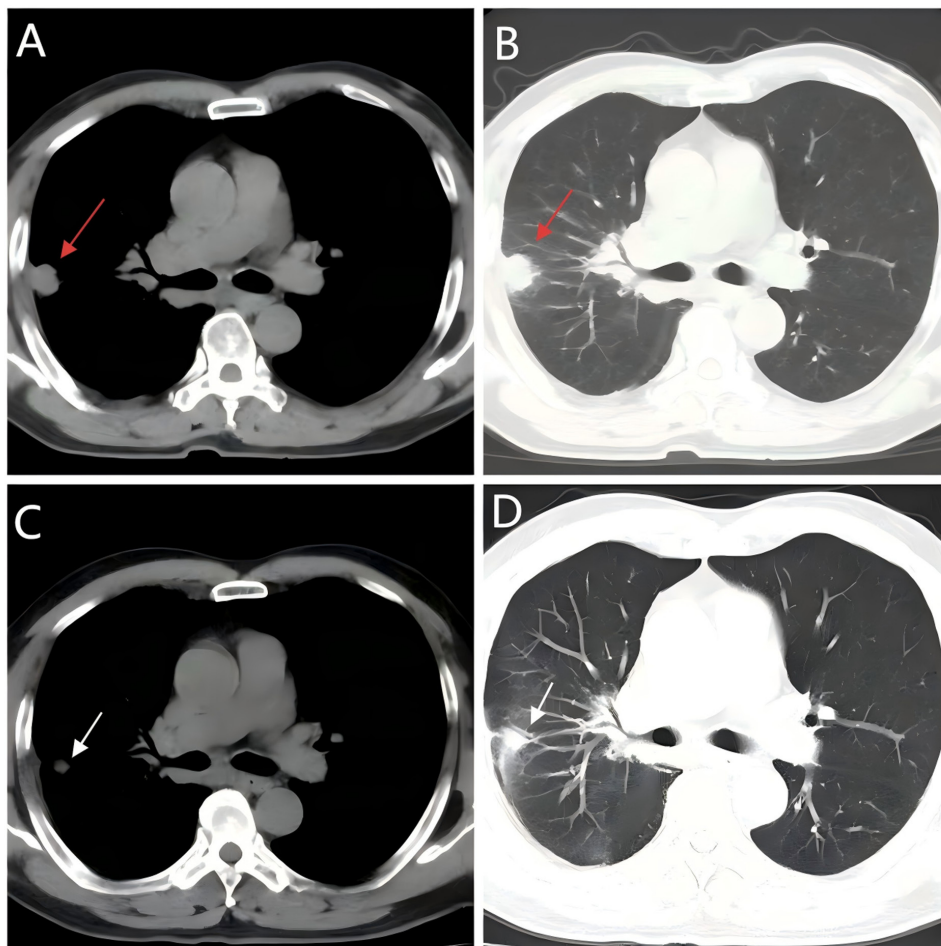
Axial chest CT scans before and after treatment. (A) Pre-treatment CT (mediastinal window) reveals a heterogeneously enhancing mass (46x35 mm) in the right lower lung lobe with suspected malignant pleural effusion and right hilar/mediastinal lymphadenopathy (red arrow). (B) Pre-treatment CT (lung window) reveals decreased aeration in the right lower lobe due to compression by the mass, along with visible pleural effusion. (C) Post-treatment CT (mediastinal window) reveals reduction in the mass size, resolution of pleural effusion, and improved lung clarity in the right lower lobe (white arrow). (D) Post-treatment (lung window) reveals improved lung clarity in the right lower lobe and re-expansion of the compressed lung tissue, with no evident pleural effusion.
